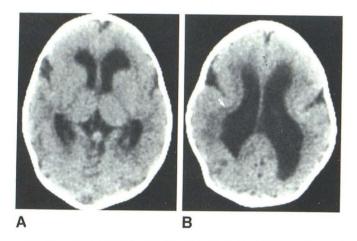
Case 5 (case 8 in [1]). Type I lissencephaly in ILS. A, CT scan at 11 days. B, Higher cut. Areas of pachygyria (e.g., immediately posterior to right sylvian fossa in B) and agyria. Ventricles are large and malformed but hydrocephalus was not present. Smooth subsurface line (*arrow*). (B reprinted from [1].)
